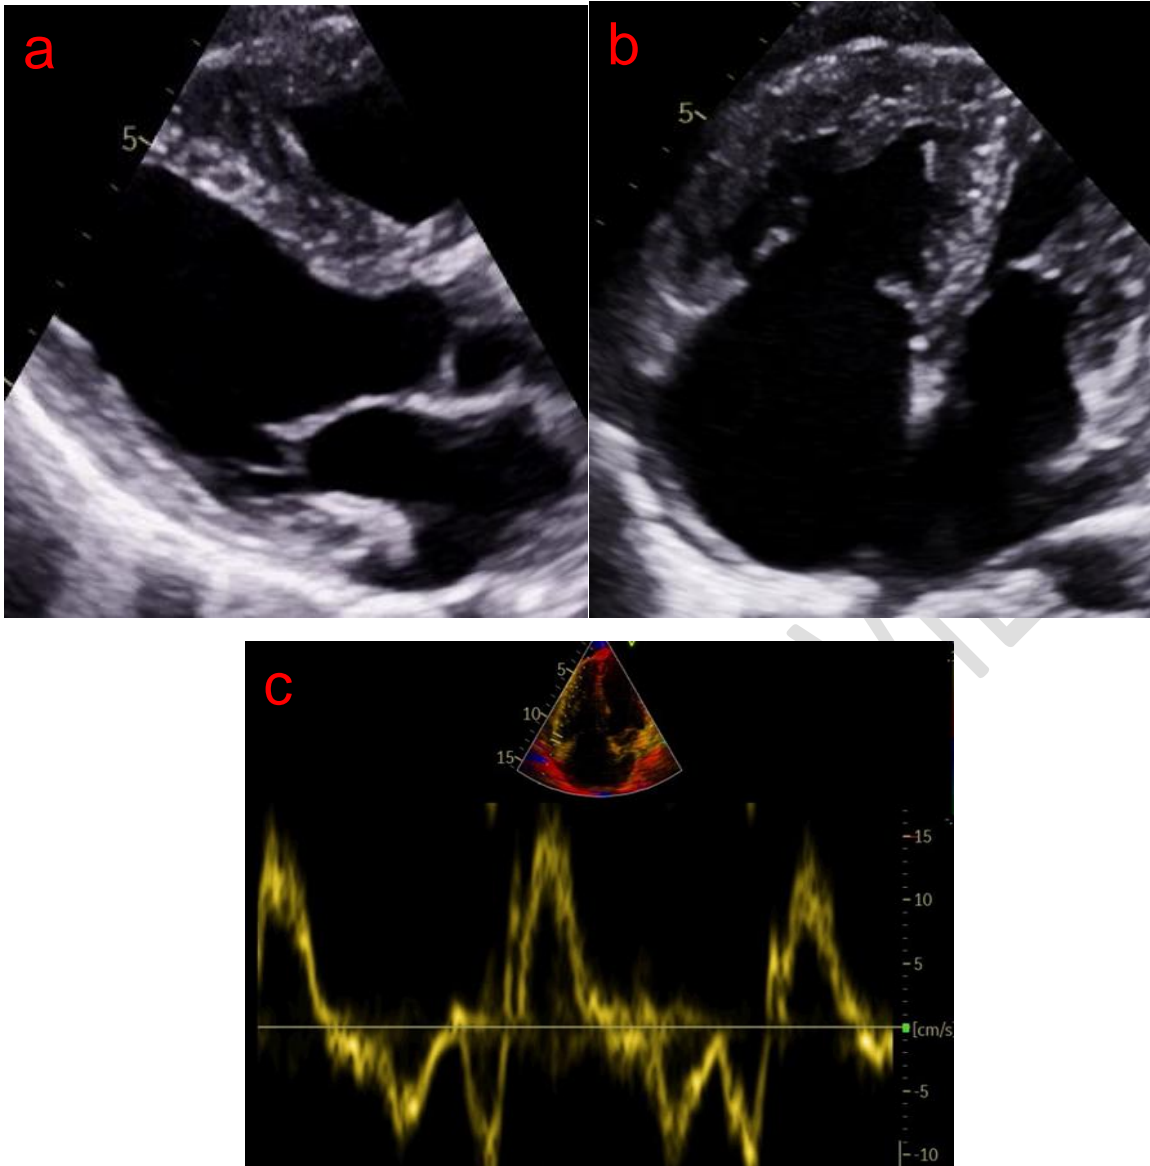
Transthoracic echocardiography (TTE): a-long axis view: non-dilated and non-hypertrophic left ventricle (TDDLV: 40mm indexed at 26mm/m²), b-4 chambers apical view: dilation of the right atrium with a surface area of 27.8cm² with dilated right ventricle (RV) and hypertrophy of the posterior wall of the right ventricle measuring 8mm thick
